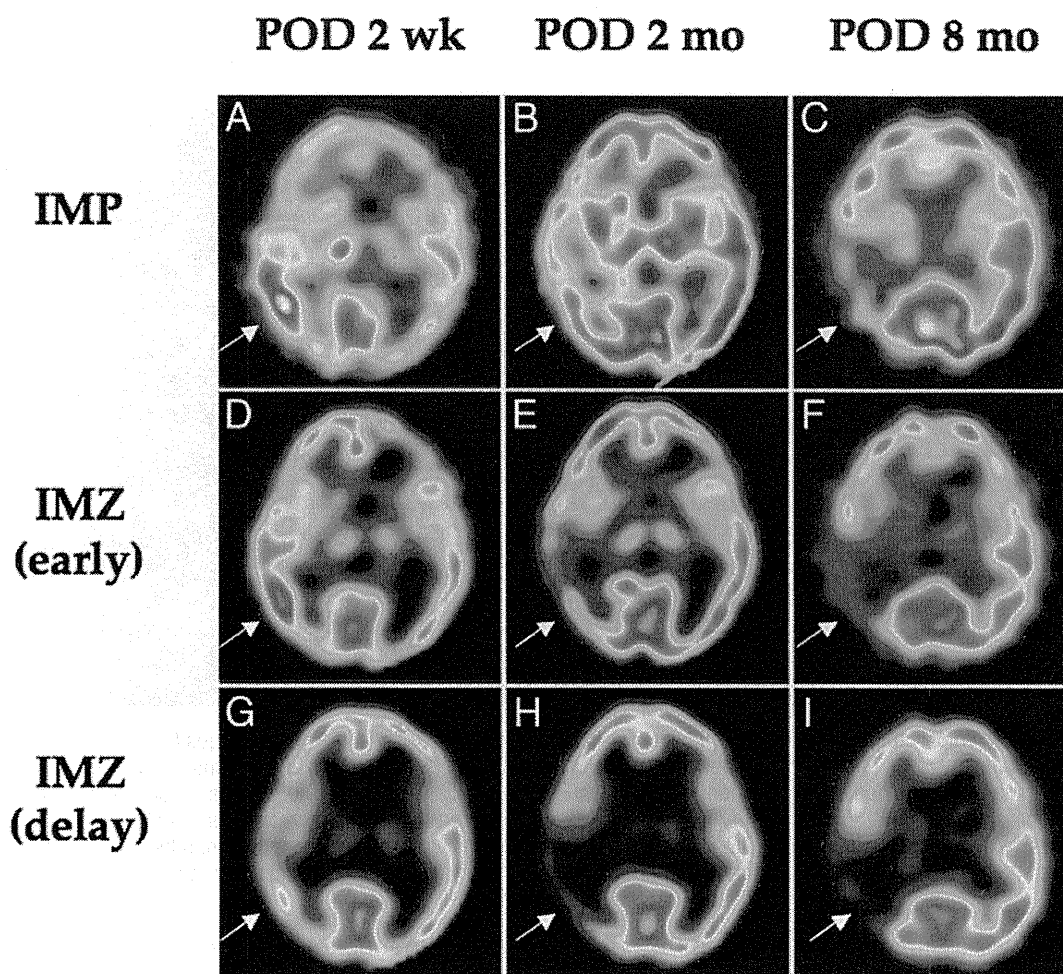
Chronological changes in ^{123}I -IMP and early and delayed ^{123}I -IMZ SPECT images. Iodine-123-labeled iodoamphetamine (A–C) and early ^{123}I -IMZ (D–F) images similarly showing a transient increase in the subacute stage (POD 2 weeks [POD 2 wk; A and D]), followed by progressive decrease in the early and late chronic stages (POD 2 months [POD 2 mo; B and E] and 8 months [POD 8 mo; C and F]) of uptake in the affected regions. Delayed images of ^{123}I -IMZ (G–I) demonstrating delayed decrease of binding of the affected regions between subacute (G) and early chronic (H) stages, which levels off in the late chronic stage (I). Arrows indicate the affected region in the temporal lobe.
